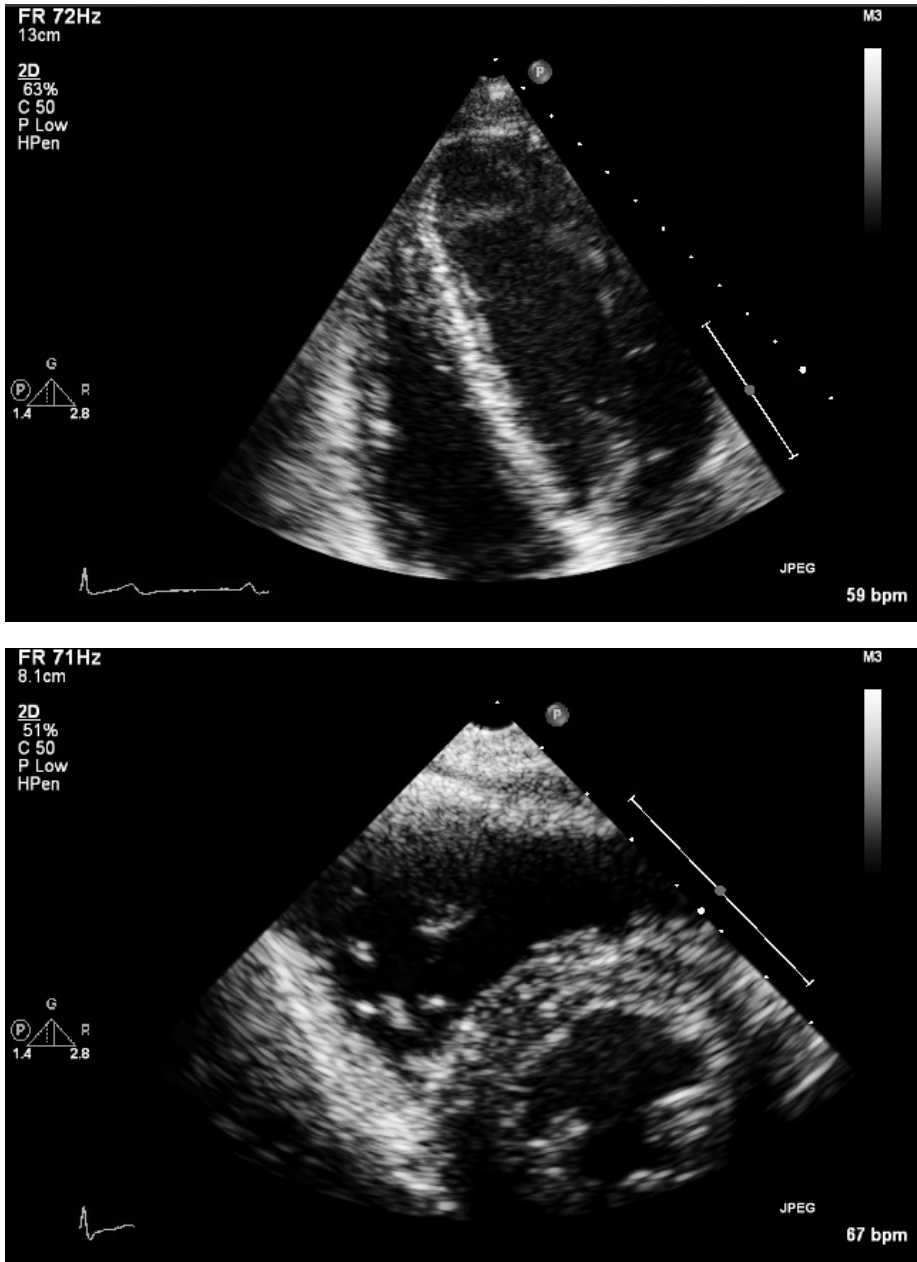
An apical four-chamber view and a short-axis view derived from two-dimensional echocardiography. The upper panel shows the triangular shape of the right ventricle when viewed from the side. The lower panel shows the crescent shape when viewed in cross section.
